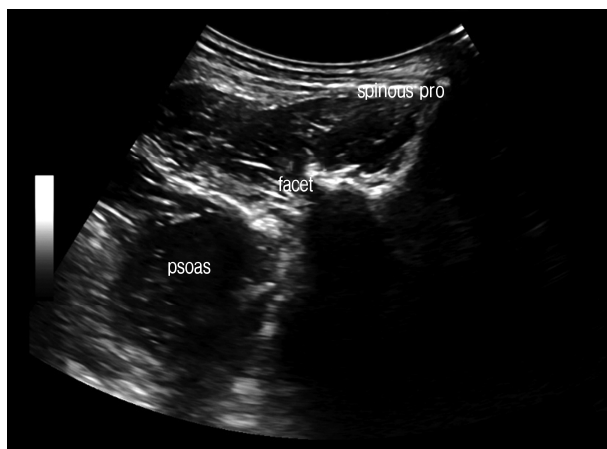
Facet as target point of prolotherapy on ultrasonography.
